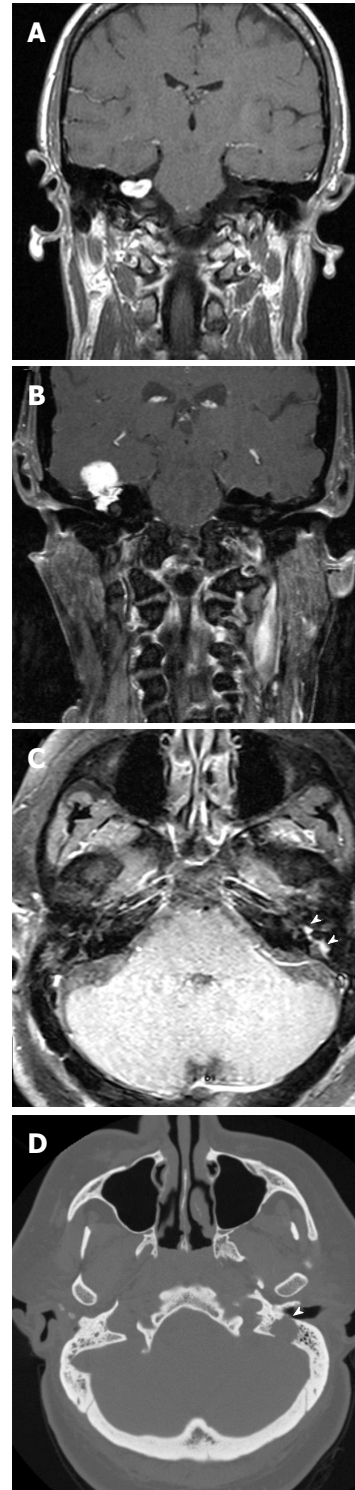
Radiographic images of facial nerve schwannoma. A: Contrasted coronal T1 weighted MRI of right intracanalicular FNS. The patient was presumed to have a vestibular schwannoma but the tumor arose from the FN. The patient underwent tumor debulking with HB grade 1 at follow-up; B: Contrasted T1 weighted coronal MRI of a large FNS arising from the geniculate ganglion with significant extension into the middle fossa and the middle ear. The patient underwent a translabyrinthine resection with cable grafting; C: Post contrast axial T1 weighted MRI demonstrating a FNS involving multiple levels of the facial nerve. This is a typical appearance of the "beads on a string" pattern of tumor growth (arrowheads); D: Axial bone window high resolution computer tomography of the temporal bone demonstrating a large FNS of the mastoid segment causing erosion of both the bony ear canal (arrowhead) and the posterior fossa plate. MRI: Magnetic resonance imaging; FNS: Facial nerve schwannoma; HB: House-Brackmann.
